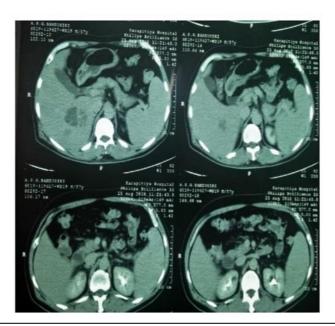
Triple phase CT abdomen CT features are in favour of 7.5x5.4x5.4cm size resolving liver abscess in segment VI and vii with multiple splenic micro abscesses and right side renal abscess. Mild splenomegaly.
